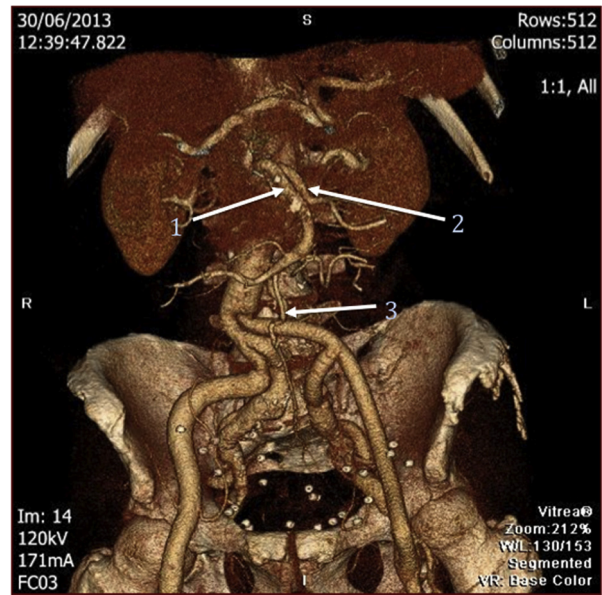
Postoperative CT angiography showing the SMA and aortoiliac reconstruction. 1, SMA inlay graft; 2, jejunal jump graft; 3, inferior mesenteric artery.
